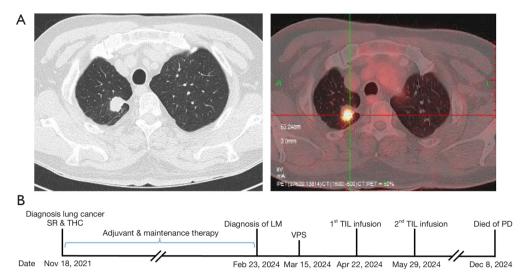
Pulmonary lesion and treatment overview for Patient ChiCTR-102. (A) PET/CT views of the pulmonary lesion in Patient ChiCTR-102. (B) Treatment overview for Patient ChiCTR-102. CT, computed tomography; LM, leptomeningeal metastasis; PD, progression disease; PET/CT, positron emission tomography/computed tomography; SR, surgical resection; THC, tissue handling and cryopreservation; TIL, tumor-infiltrating lymphocyte; VPS, ventriculoperitoneal shunt.
